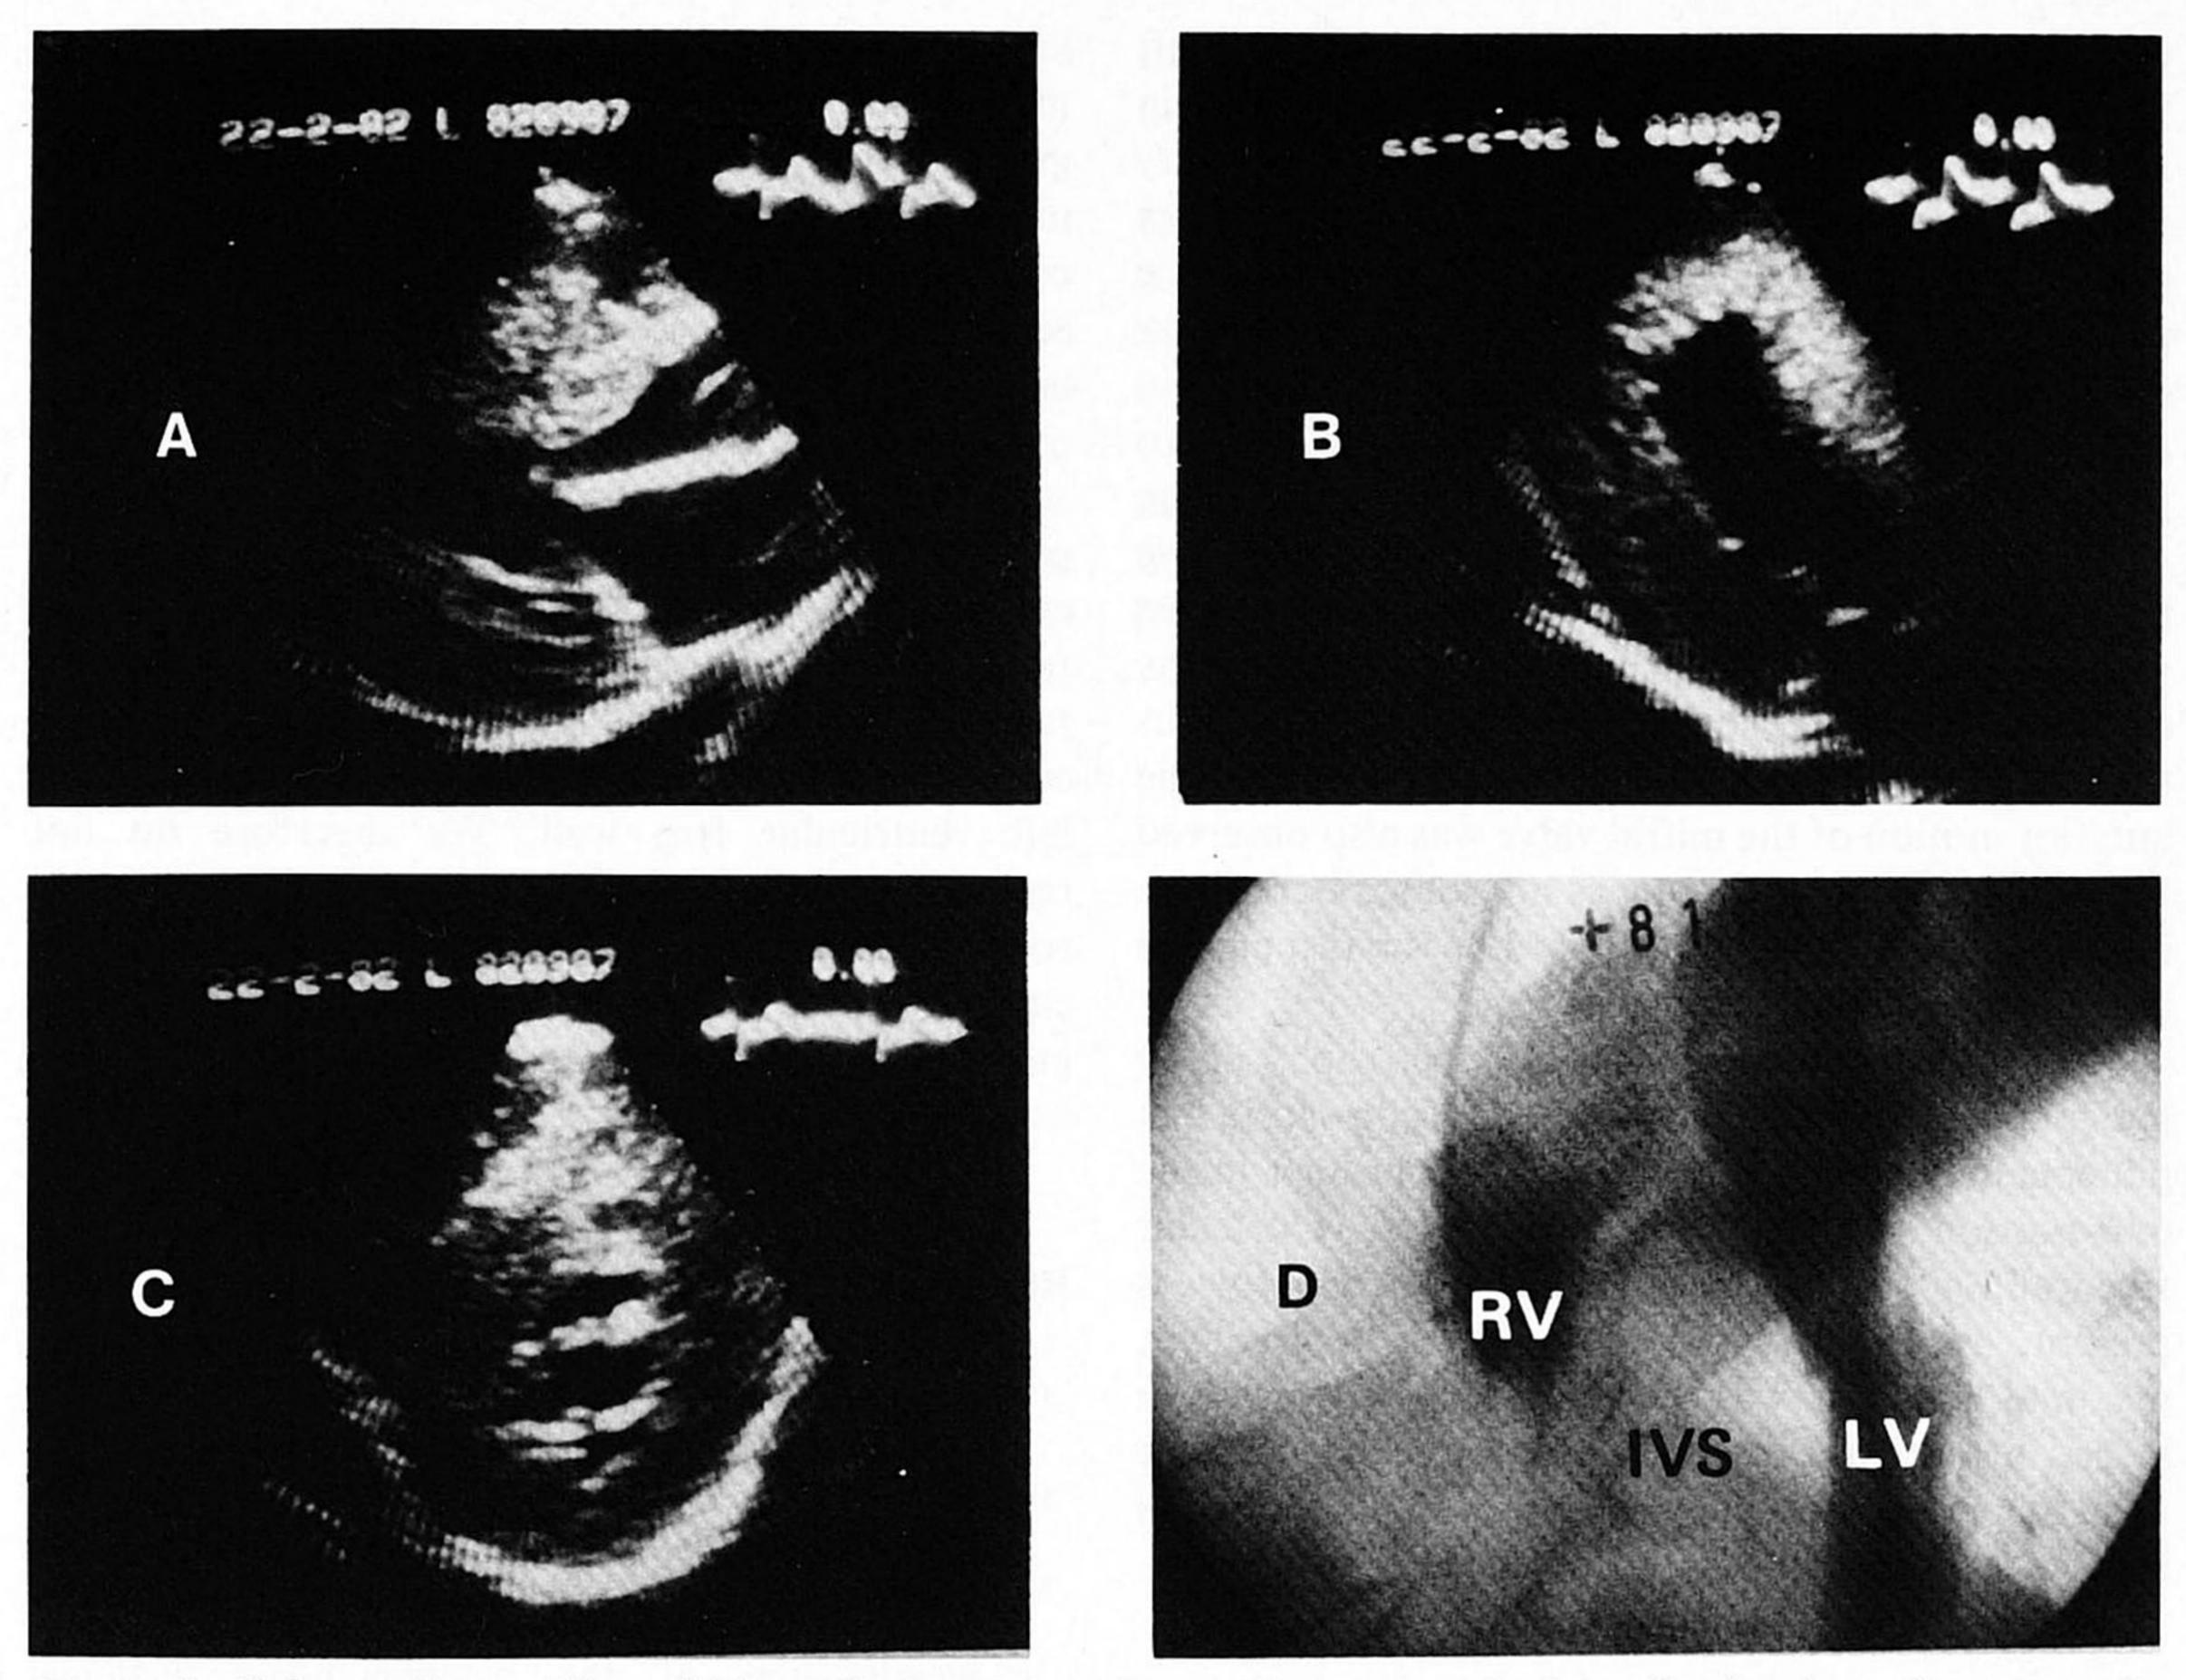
Echocardiographic and biventricular cineangiographic portrayal of the distribution of hypertrophy in a patient with hypertrophic cardiomyopathy. Echocardiographic views showing concentric hypertrophy (ABC) and biventricular cineangiogram showing marked septal hypertrophy (D).
